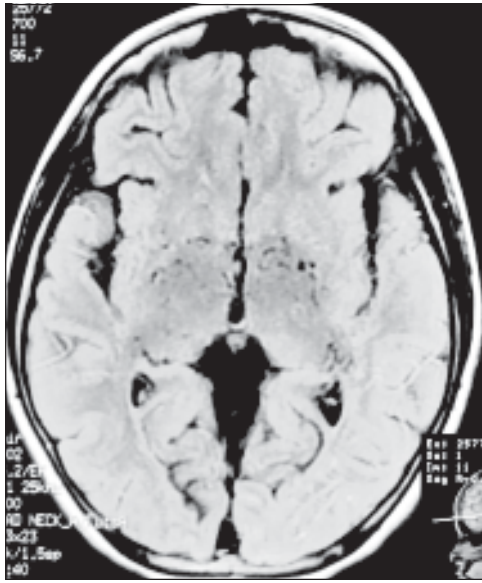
FLAIR image of MRI (Axial view) showing multiple flow voids in the area of circle of Willis and in the basal ganglia.
